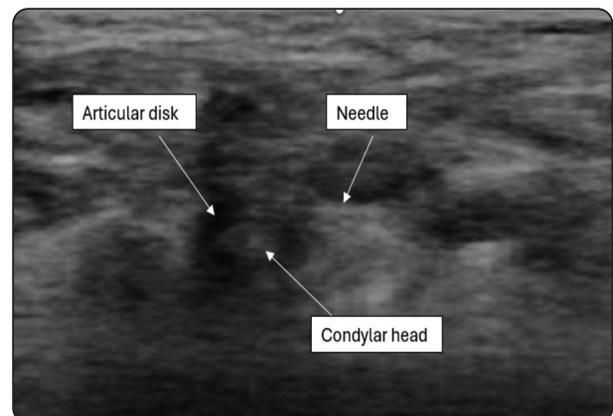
Showing needle placement using ultrasound guidance.
